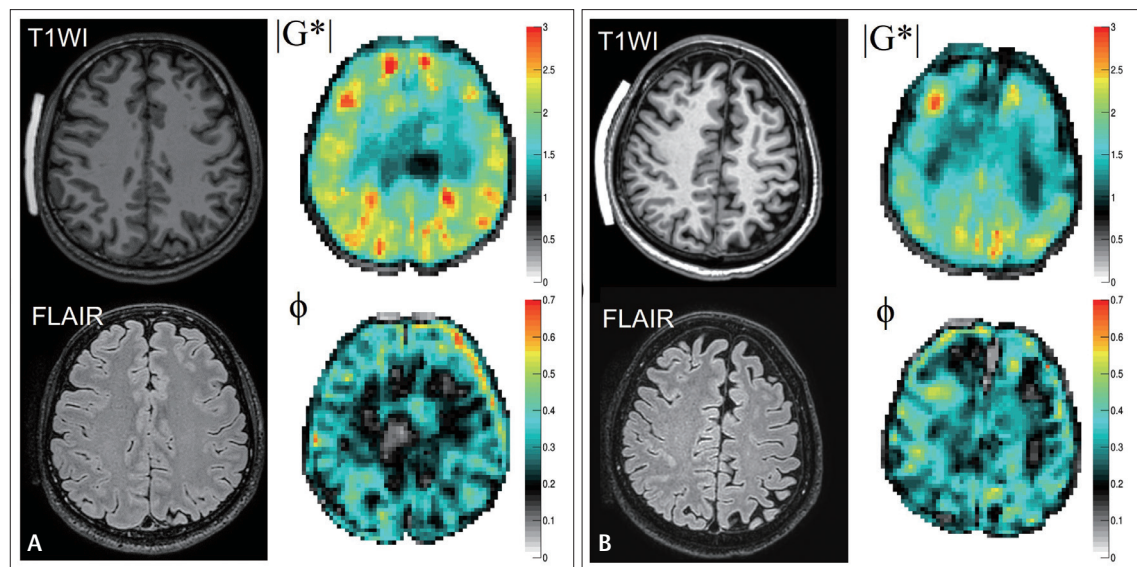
Examples of brain MRE of a 34-year-old male (A) and a 70-year-old male (B). The younger participant in (A) showed a higher magnitude of the complex shear modulus ($|G^*|$) than the older participant in (B). Adapted from Joo et al. [31], Korean J Radiol 2023;24:564–573, under CC BY NC license. MRE, magnetic resonance elastography; T1WI, T1-weighted imaging; FLAIR, fluid-attenuated inversion recovery imaging; ϕ , phase angle of the complex shear modulus.
